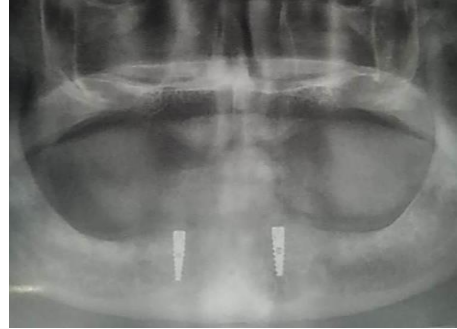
Radiographic evaluation after placement
